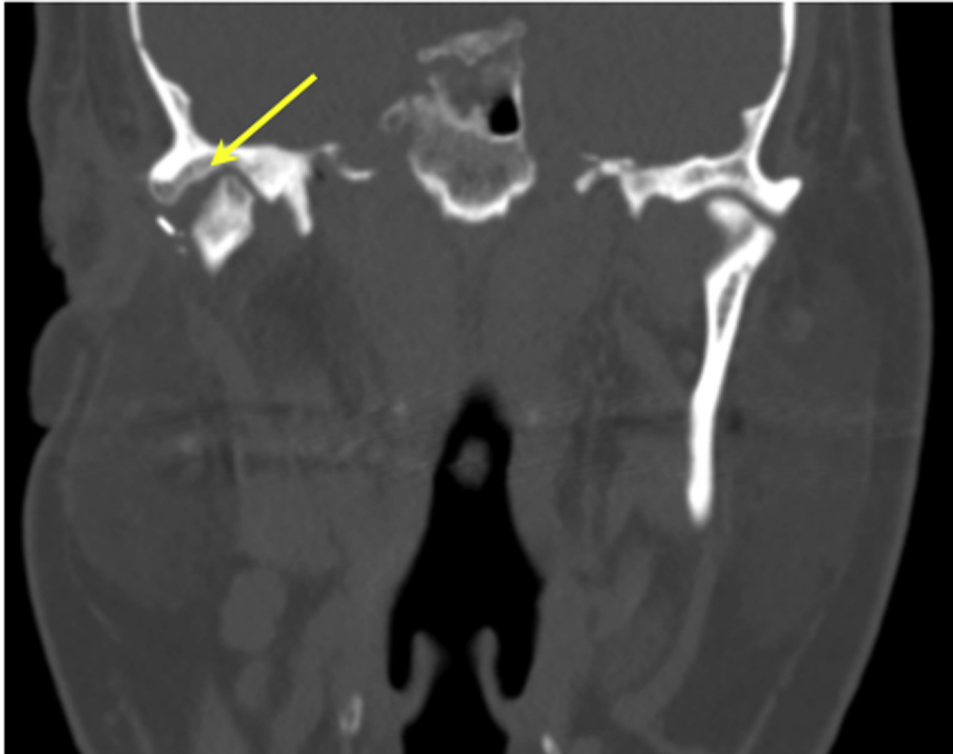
Postoperative computed tomography coronal image of a 47-year-old male patient with a diagnosis of right temporomandibular joint degenerative joint disease showing tissue regeneration (arrow) in the area of the glenoid fossa ~17 months postoperatively.
